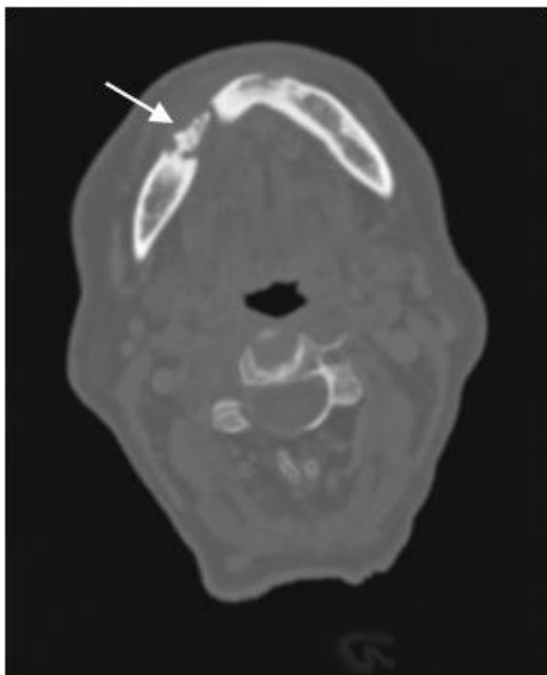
mandibular tuberculosis; facial CT scan in axial section, the arrows showing a right parasymphseal osteolytic process type Ib of Lodwick with bone sequestration
